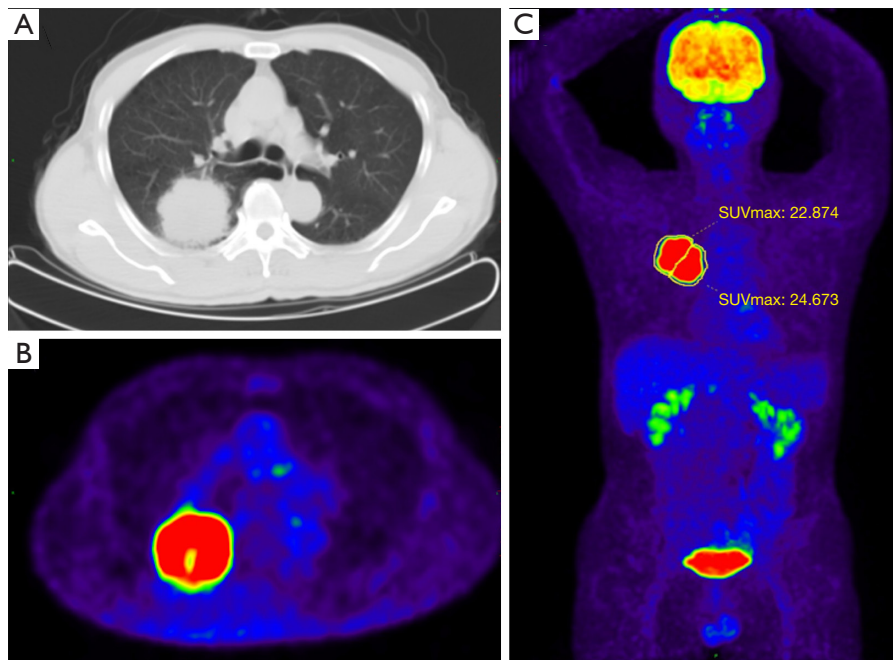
Images from a 69-year-old male patient with adenocarcinoma. Transaxial CT (A) showed a soft mass in the right upper lobe. The mass presented profound 2-¹⁸F]FDG uptake on transaxial PET image (B). The SUVmax values of the pSUVmax and dSUVmax regions were 24.673 and 22.874, respectively (C). The ratio of pSUVmax to dSUVmax was calculated as 1.079, which indicated a malignant lesion. PET, positron emission tomography; SUVmax, maximum standard uptake value; pSUVmax, proximal SUVmax; dSUVmax, distal SUVmax.
